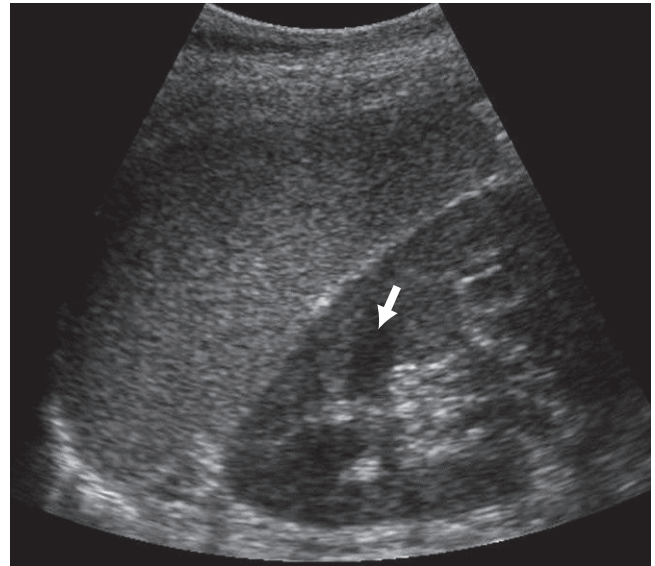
Real-time ultrasound image demonstrates a normal left kidney seen along with the spleen, which is considerably more echogenic compared to the kidney. Hypochoic renal medullary pyramids are seen (arrow).
